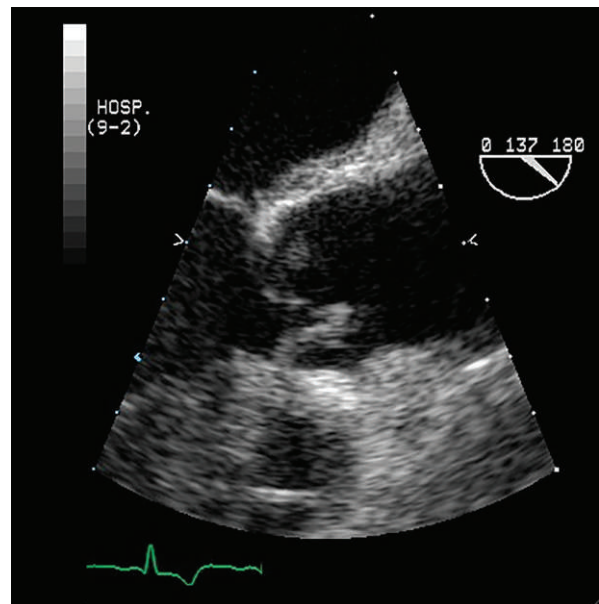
Intraoperative transesophageal echocardiogram after aortic valve repair shows a coaptation height above the aortoventricular junction and a coaptation length of 0.9 cm.
